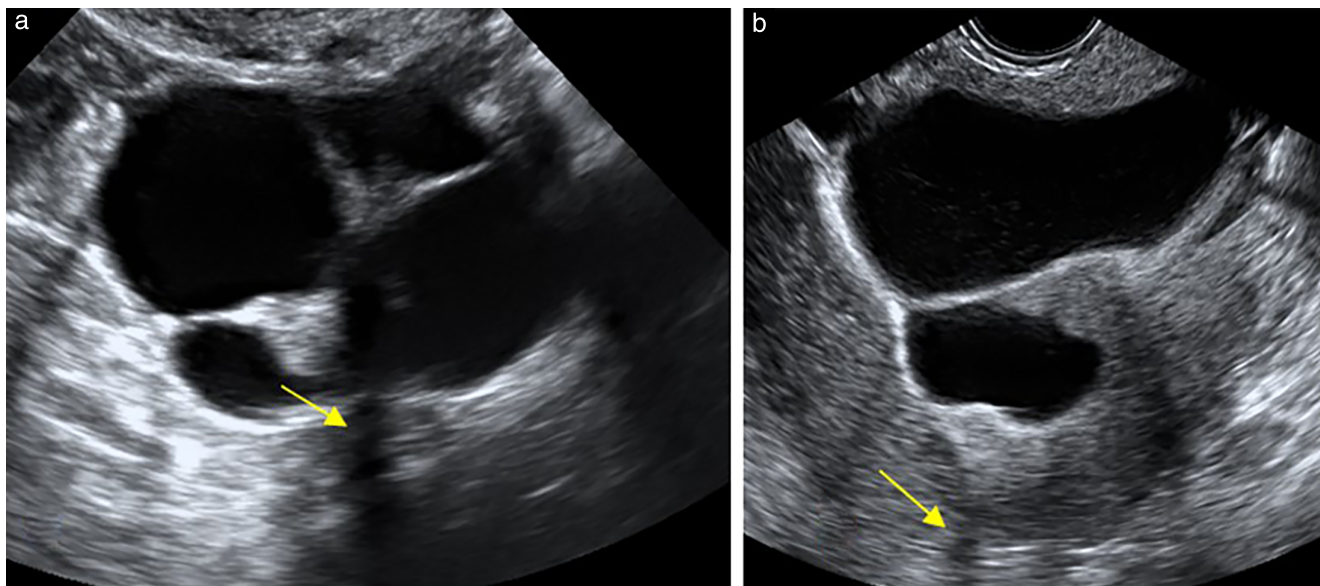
Grayscale ultrasound images of multilocular solid serous cystadenofibromas with solid components but no papillary projections: (a) in 52-year-old woman, showing small solid components with shadowing (arrow); and (b) in 77-year-old woman, showing large solid component with shadowing (arrow).
